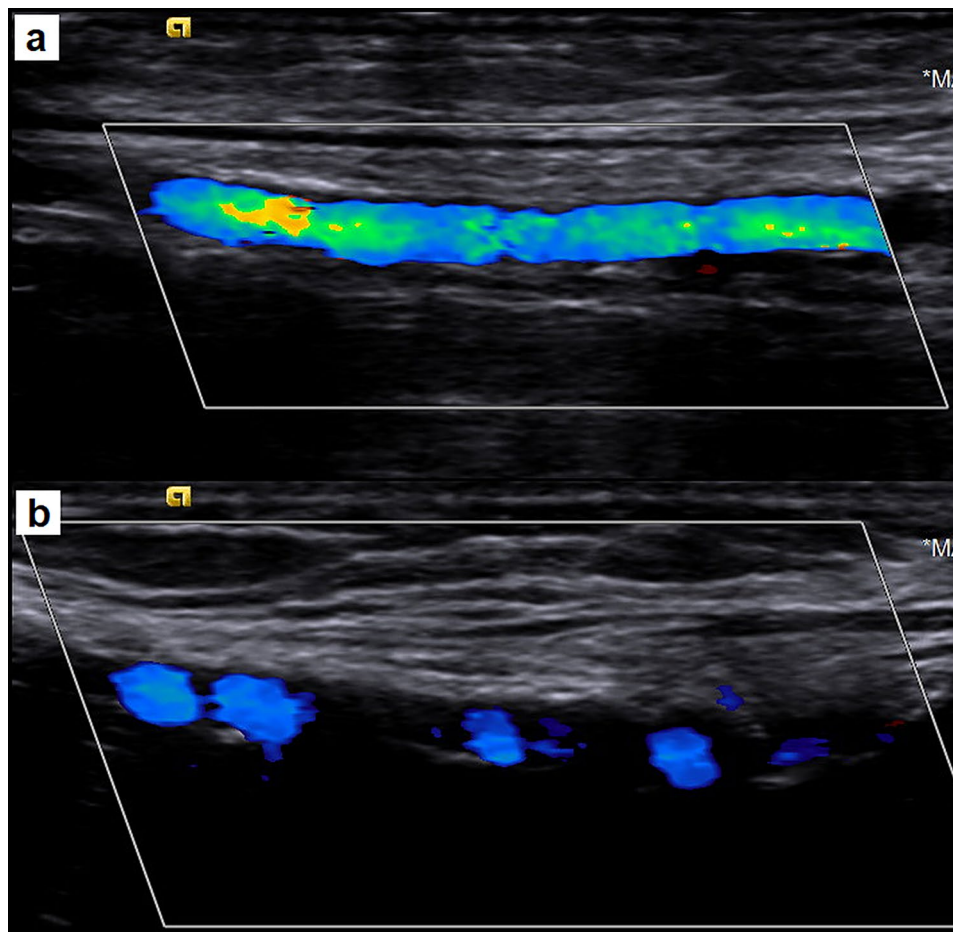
Color Doppler assessment of arterial calcifications: panel a - homogeneous color Doppler (> 50% of visible length of the artery colored), panel b - patchy color Doppler (< 50% colored)
